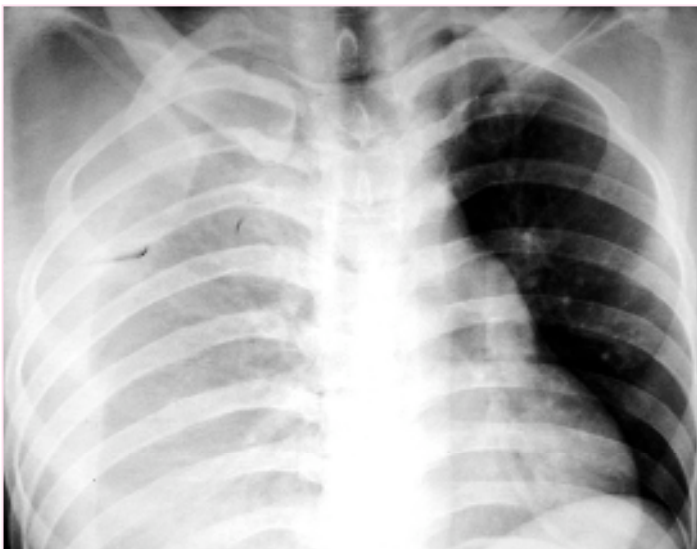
A chest roentgenogram demonstrated hemothorax in right hemithorax.
